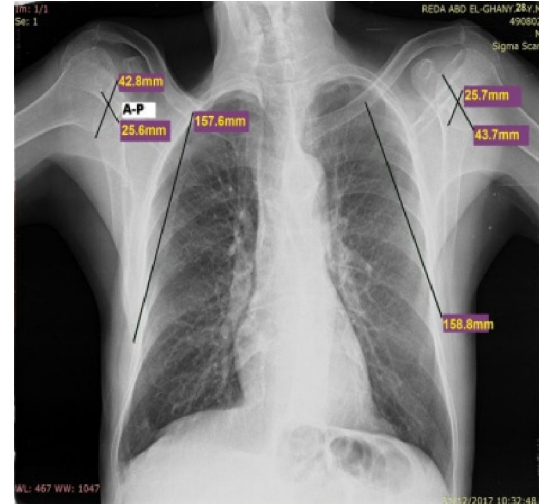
A photograph of plain x-ray of the chest of male aged 28 years showing the parameters of the scapula measured from the anteroposterior roentgenograms of the chest. On left side, Maximum Scapular Length (MSL) is 158.8 mm, Glenoid Superior-Inferior diameter is 43.7 mm, Glenoid Anterior-Posterior diameter is 25.7mm. on the right side, Maximum Scapular Length (MSL) is 157.6 mm, Glenoid Superior-Inferior diameter is 42.8 mm, Glenoid Anterior-Posterior diameter is 25.6 mm
